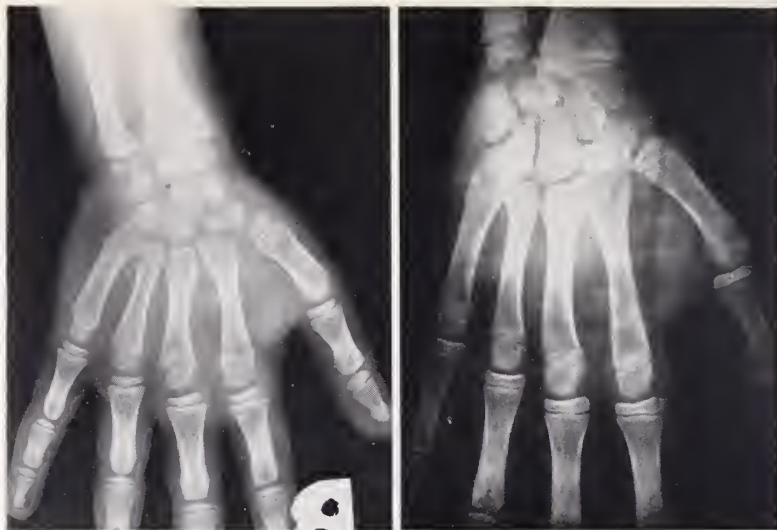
(Left) Normal wrist roentgenograms of a boy at age 14 years. The spaces between epiphyses and diaphyses in the phalanges are narrow. Metacarpal epiphyses have begun union with their diaphyses. There is a definite beak on the ulnar side of the radial epiphyses. (Right) Wrist roentgenograms of patient J. M., which is similar to the standard for age 7 years. The ulnar epiphysis is just beginning to calcify. The pisiforme is still absent. The greater and lesser multangulare and noviculare are small and do not show their final forms. The epiphyses are narrower than the bones with which they will eventually unite. The spaces between the epiphyses and diaphyses are still quite wide. Note difference in size of hands.
